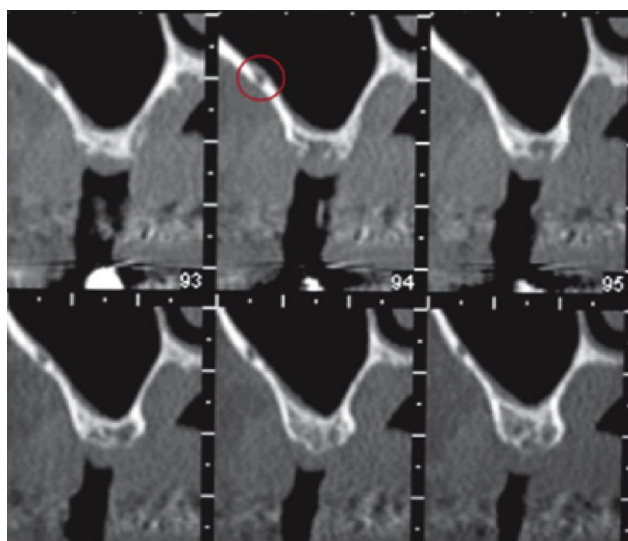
Cone beam computerized tomography of a patient who had a large hematoma after a sinus lift. Red circle indicates vessel in the bony of the maxillary sinus
